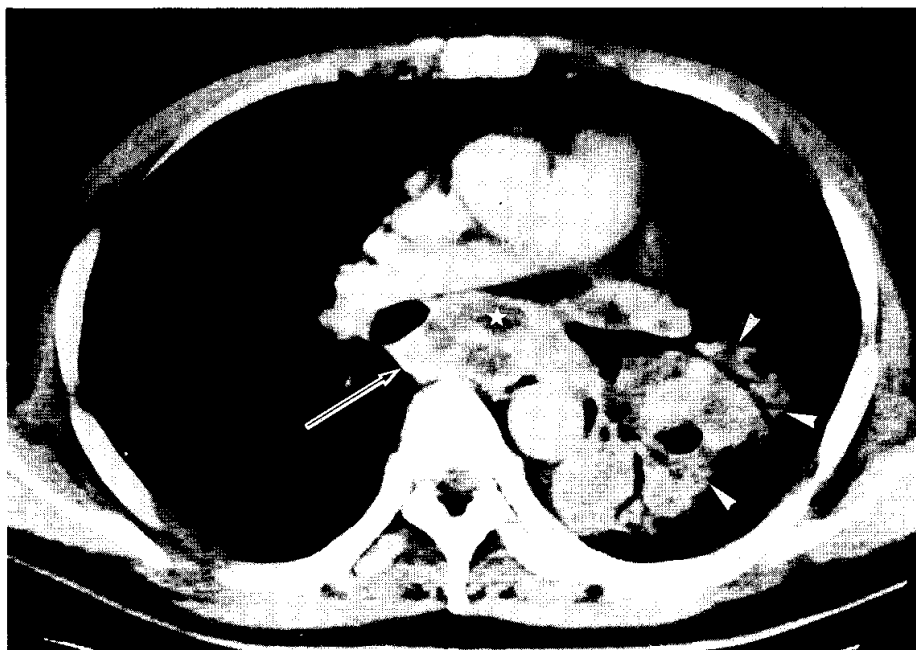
CT scans in a 35-year-old man with acquired immunodeficiency syndrome (AIDS) and pulmonary tuberculosis.
